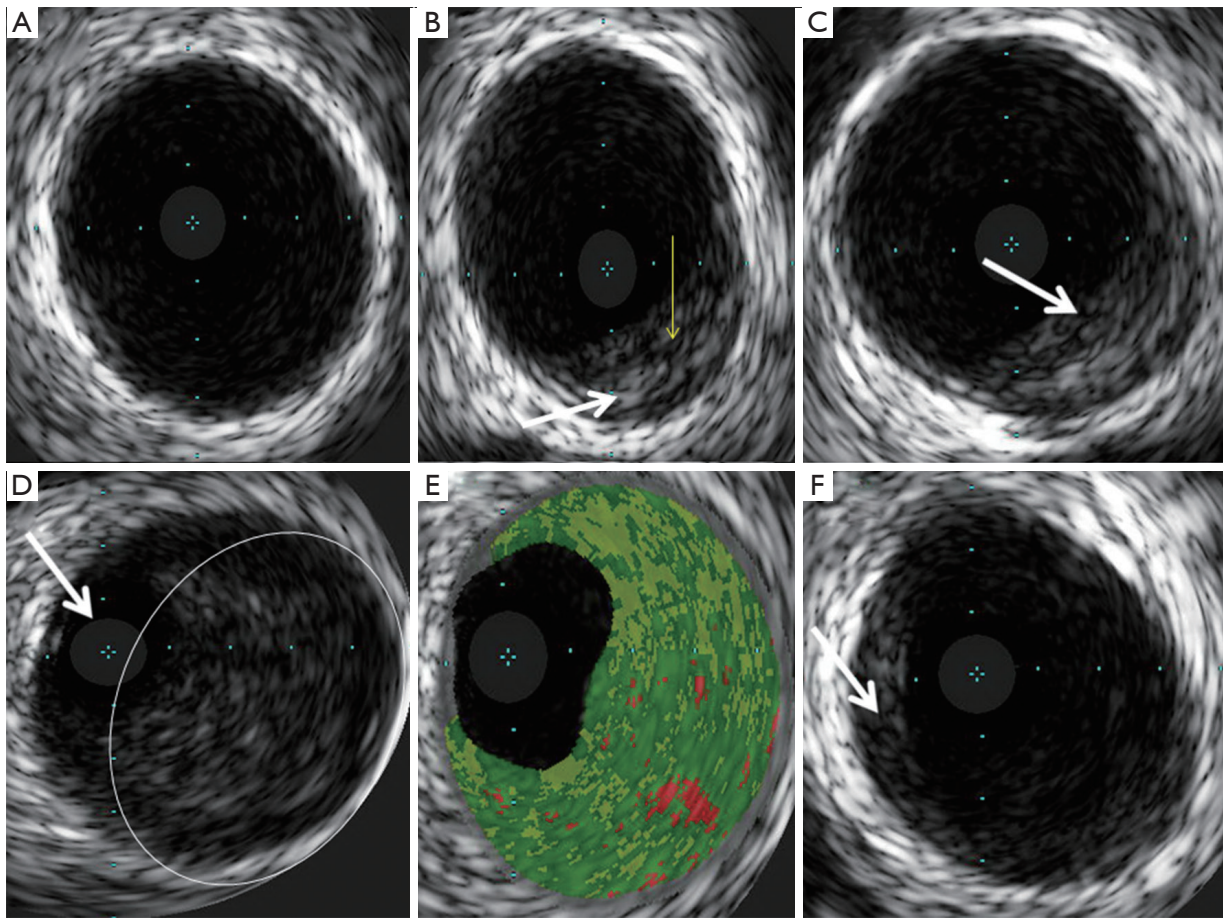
Intravascular ultrasound frames detailing nature of thrombosis.
